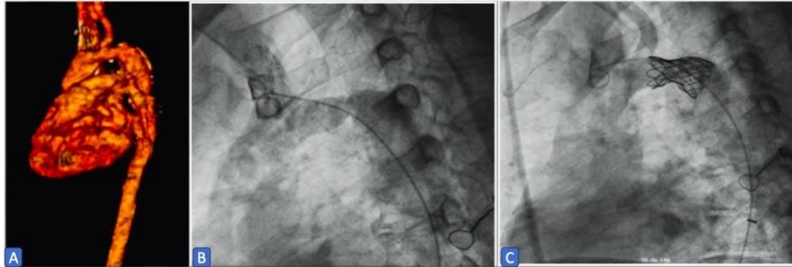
Computed tomography angiography with 3D reconstruction of the aortic arch and descending aorta where the recoarctation site is visualized (A). Diagnostic aortogram (B). Aortogram after endovascular stent implantation (C).
